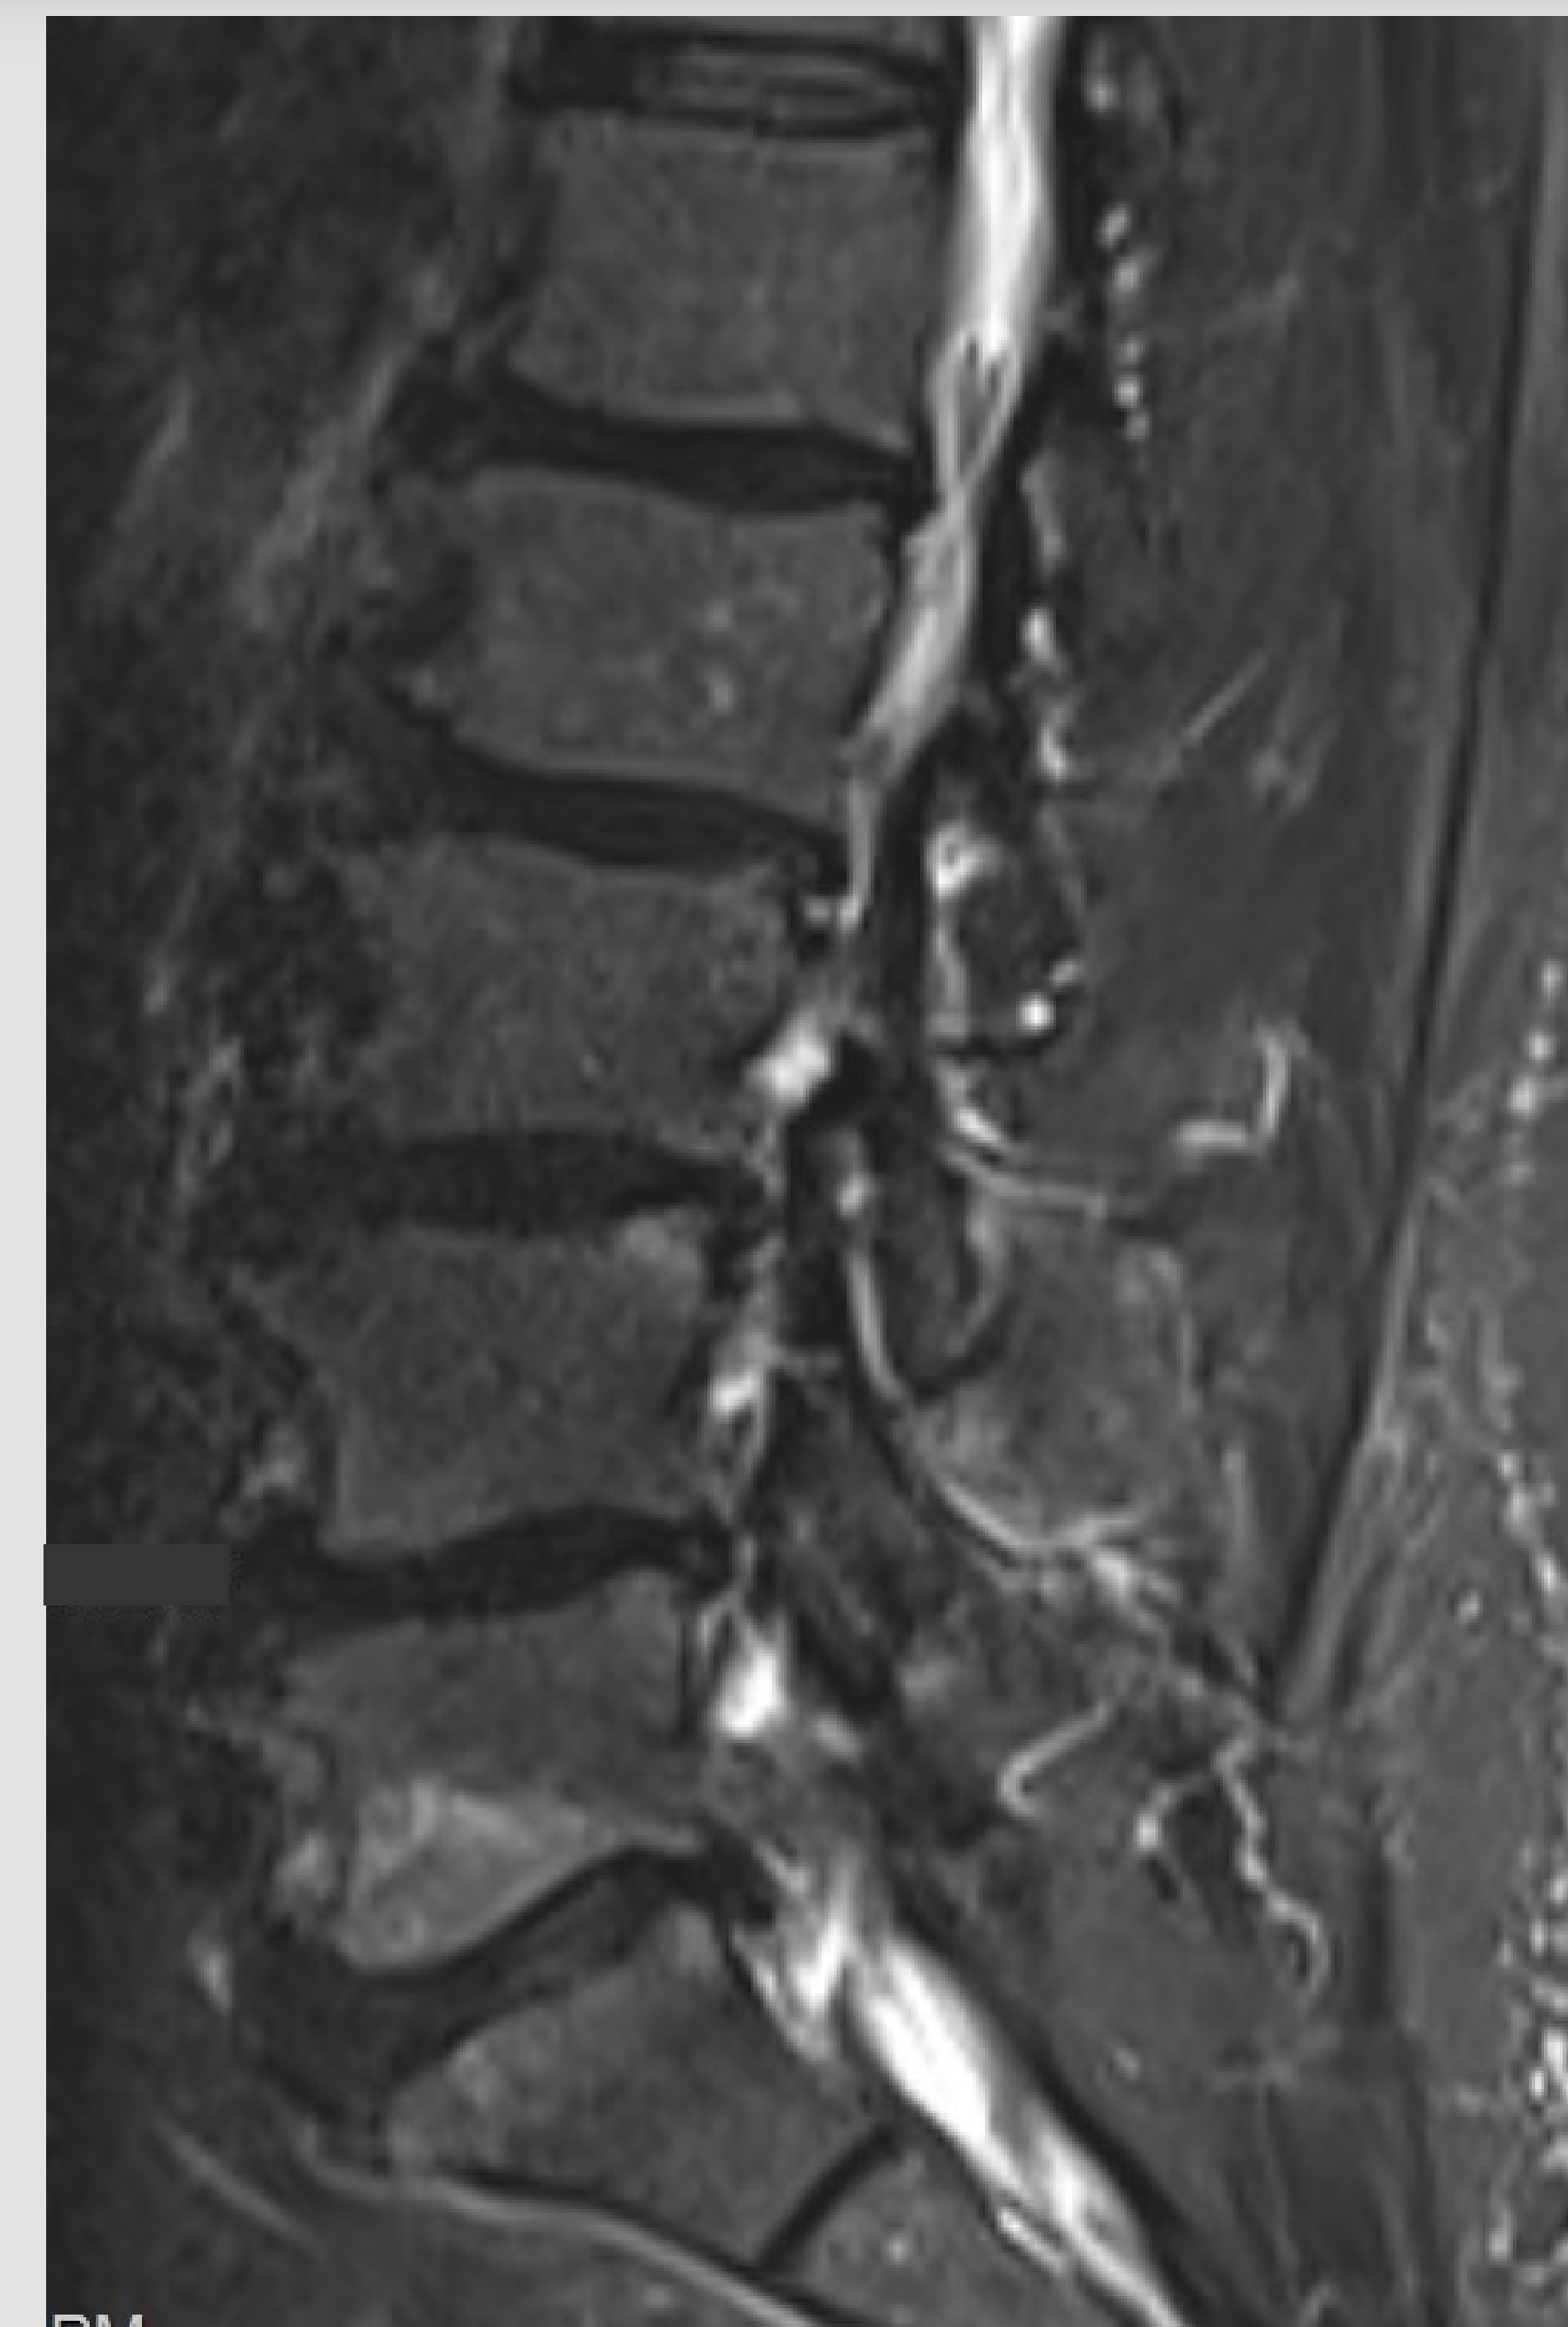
L5-S1 MODIC I CHANGES ON MRI
